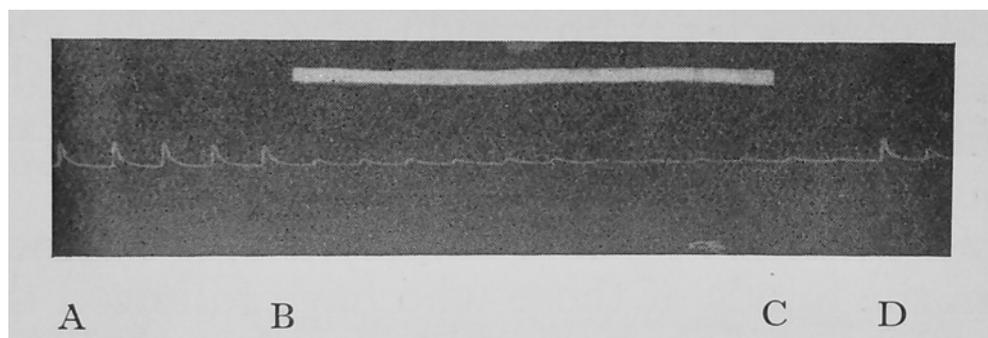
Inhibition of nerve conduction due to ultrasound exposure from B to C. (Hopwood, 1931). [55]
